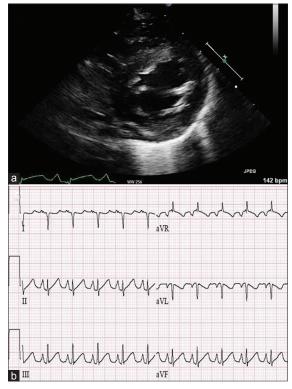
(a) (Transthoracic parasternal short-axis view) moderate left ventricular dilation and normal right ventricular size; 7 weeks of age; (b) Q waves in leads I and AVL suggestive of anomalous left coronary artery from the pulmonary artery; 7 weeks of age
